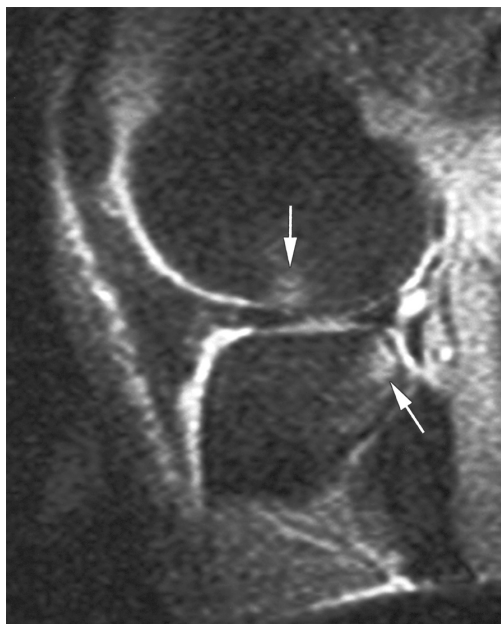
Short inversion time inversion-recovery MR image (1160/24, 192 x 128, 6-mm section thickness) shows that associated bone marrow edema (arrows) is visible in the lateral femoral condyle and the posterolateral tibial plateau.
